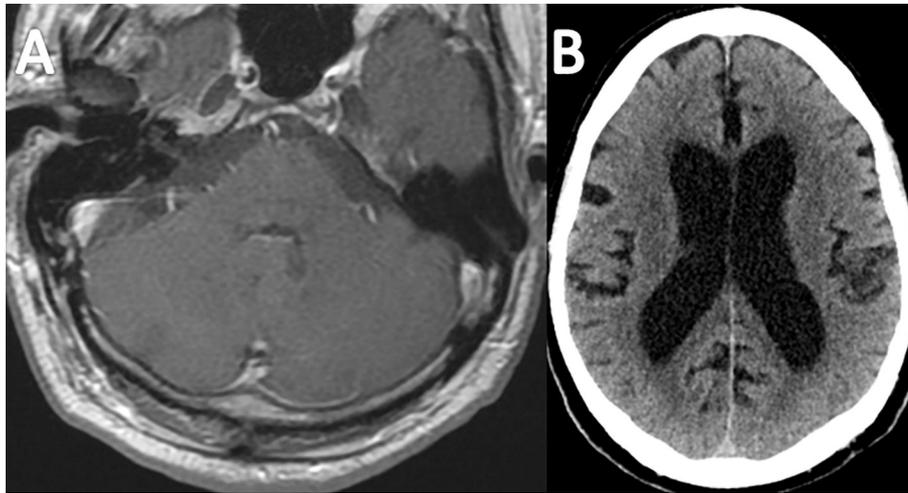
A) T1-axial MRI brain with gadolinium demonstrating no abnormal enhancement in the cerebellum or pons; and B) Axial head CT depicting mild ventriculomegaly at the time of presentation.
